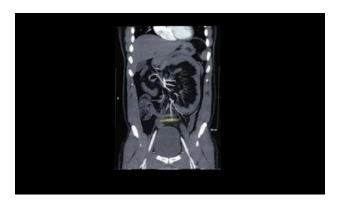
Coronal view of abdominal computed tomography scan showing internal hernia.
